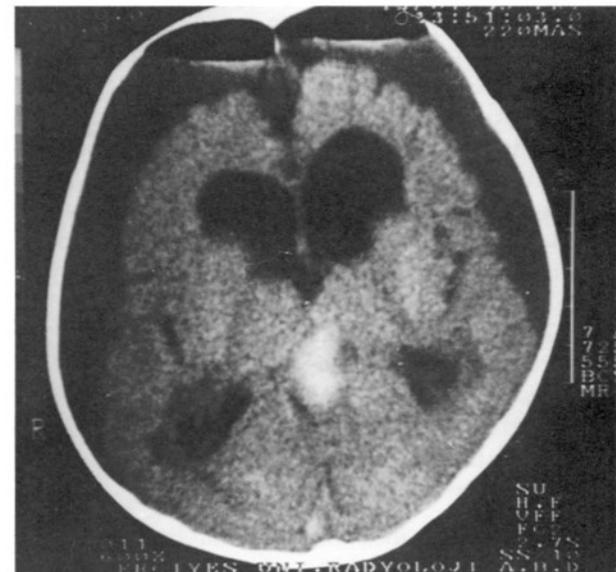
Postoperative CT scan shows the collapsed aneurysmal sac and subdural fluid accumulation.
